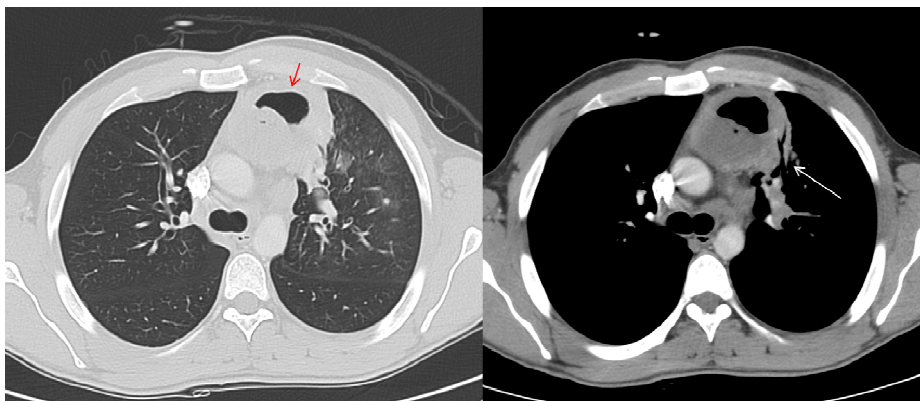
Images from a CT scan
